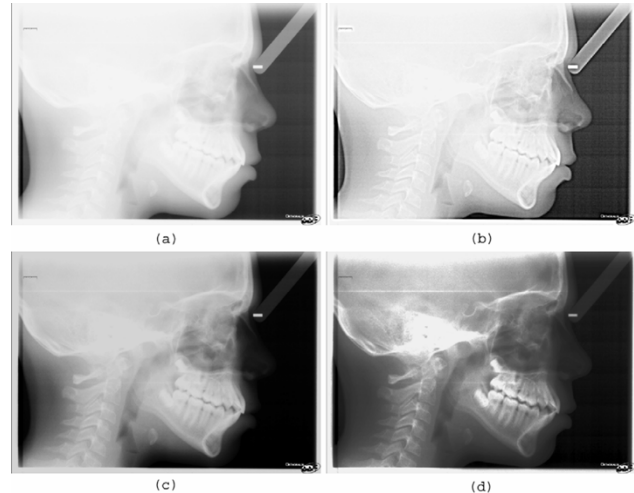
(a) Typical cephalic radiography, 1871×2605 pixels. (b) Same image treated with UM: the high frequencies are enhanced, but noise is increased, whereas bone is still not clearly visible. (c) Same image after GC, using $\gamma = 0.25$. Although the number of GLs used by the bone pixels (brighter levels) has increased, the range of the dark ones is compressed. (d) Same image after IE. Both GC and IE enhance the bony pixels, but the soft tissue darkens and tends to mix with the background. The same image treated with the proposed filter is shown in Fig. 5(h).
